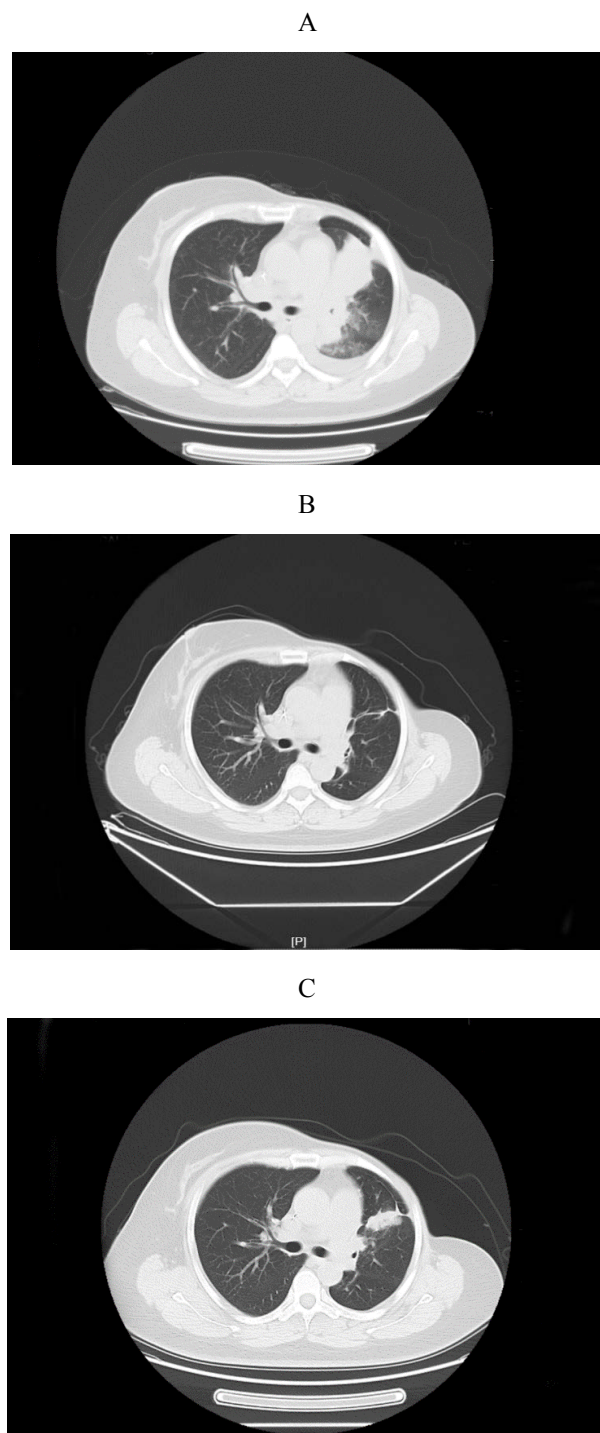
A) CT (2018-7-27) demonstrates the largest lung metastasis before oral pyrotinib. B) Lung metastasis is significantly reduced in size after one month of pyrotinib. C) After 7 months of pyrotinib, CT (2019-3-12) scan reveals that lung metastasis is enlarged again.
